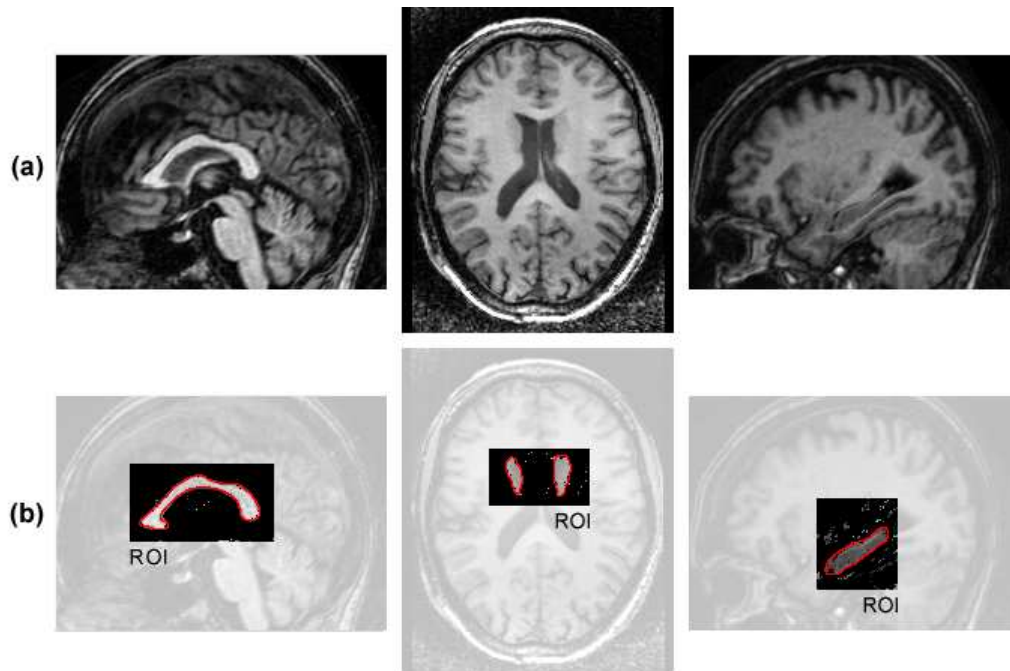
Neural classification of corpus callosum, caudate nucleus and hippocampus: (a) input T1-weighted 1mm<sup>3</sup> MRI; (b) neural extracted structures with true outlines superimposed.
